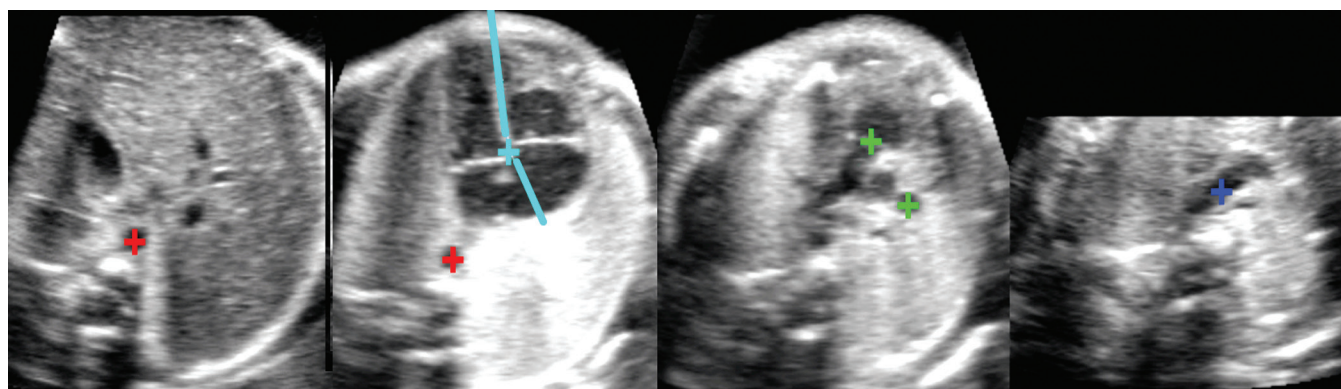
Fetal intelligent navigation echocardiography (FINE=5D heart) modality in the early stage. Required anatomical landmarks, which need to be highlighted by the examiner
